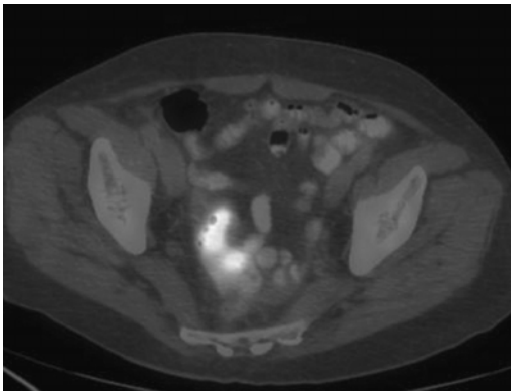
Axial fusion PET/CT image demonstrates intense focal radiotracer uptake in a primary sigmoid colon mass.
